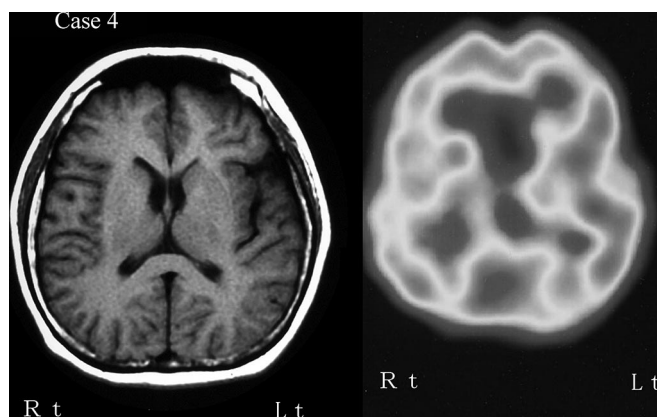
MRI and SPECT findings of case 4. Left: T1-weighted MR image (TR/TE = 300/14.0 milliseconds). Right: ^{123}I -IMP SPECT (early image).
